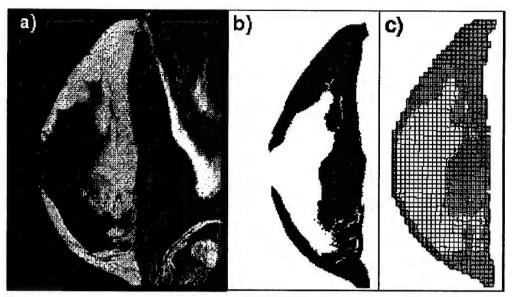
A breast MR image (a), corresponding segmented image (b), and FE mesh of a single slice (c).
